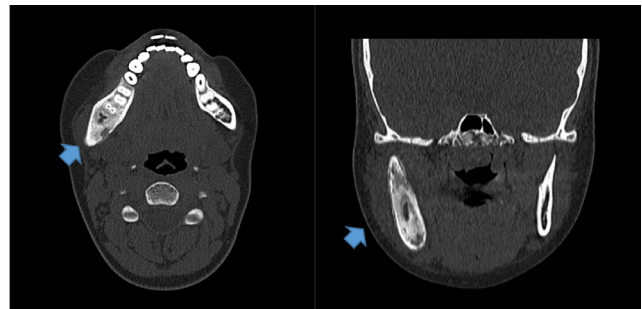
Axial (a) and coronal reformatted (b) CT images show bony expansion, cortical thinning, and periosteal reactions at the right mandibular body, angle, and ramus
